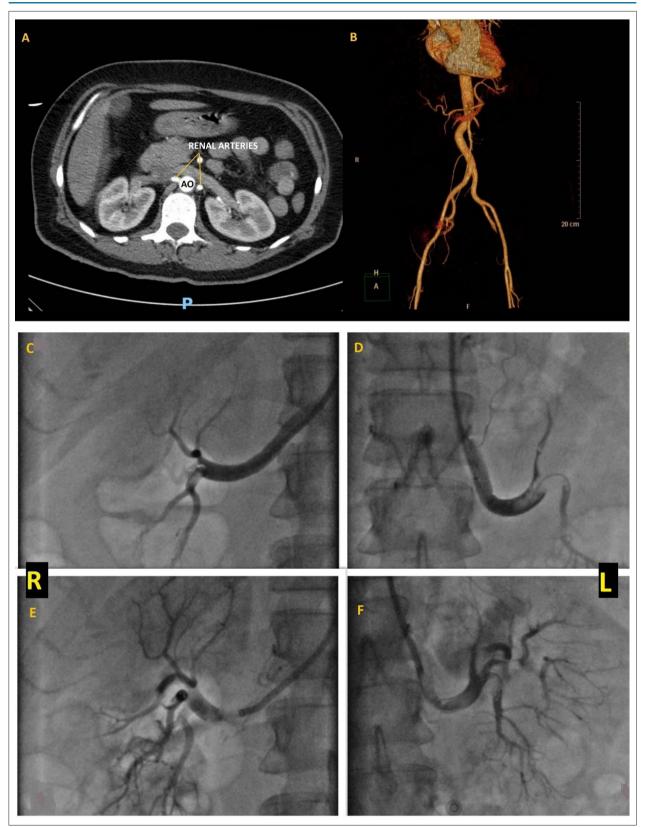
Abdominal Computed Tomography after thrombolysis showing occlusion of both renal arteries. Panel A – transversal section – renal arteries are seen only at the emergence, followed by complete occlusion of both arteries. Panel B – 3D reconstruction, showing no blood flow in the renal arteries. Panel C and D: the absence of flow/low flow in right and left renal arteries, before thrombectomy. Panel E and F: flow in both renal arteries after successful aspiration thrombectomy.
